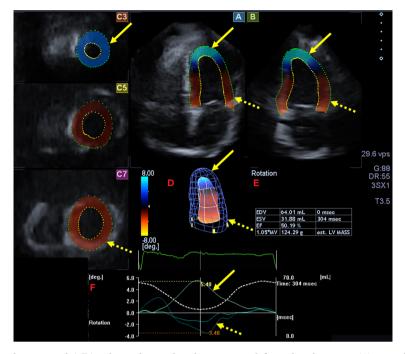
Analysis of a three-dimensional (3D) echocardiographic dataset: apical four-chamber view (A), apical two-chamber view (B) and apical (C3), mid-ventricular (C5), and basal LV (C7) short-axis views. A virtual 3D cast of the LV (red D), LV volumetric data respecting the cardiac cycle (red E), LV rotational curves (lines) and time-LV volume changes (dashed line) during the cardiac cycle (red F) are presented in a hemophilia patient with normal directions of LV rotational curves. Yellow arrow indicates maximum counterclockwise LV apical rotation, while dashed yellow arrow indicates maximum clockwise LV basal rotation. LV, left ventricle; EDV, end-diastolic volume; ESV, end-systolic volume; EF, ejection fraction.
